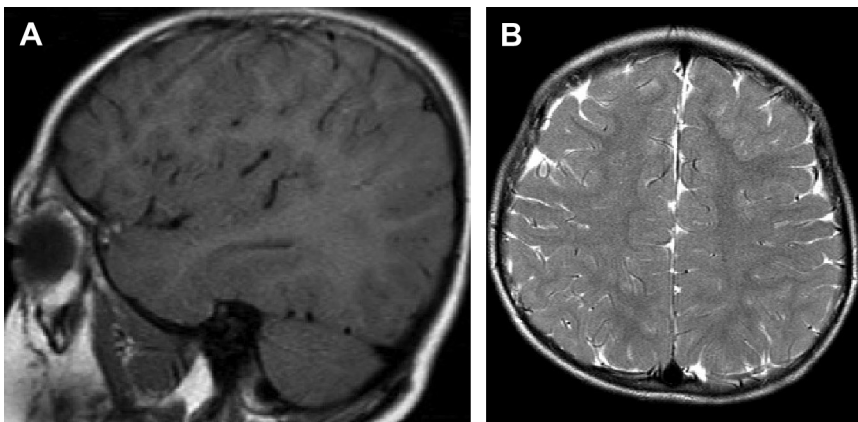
Six-year-old boy with 18q22 deletion cleft lip, hypotonia, and developmental delay. Notice the normal myelination pattern on the sagittal T1-weighted image (A) but poor deep/subcortical white matter myelination on axial T2-weighted imaging (B).
